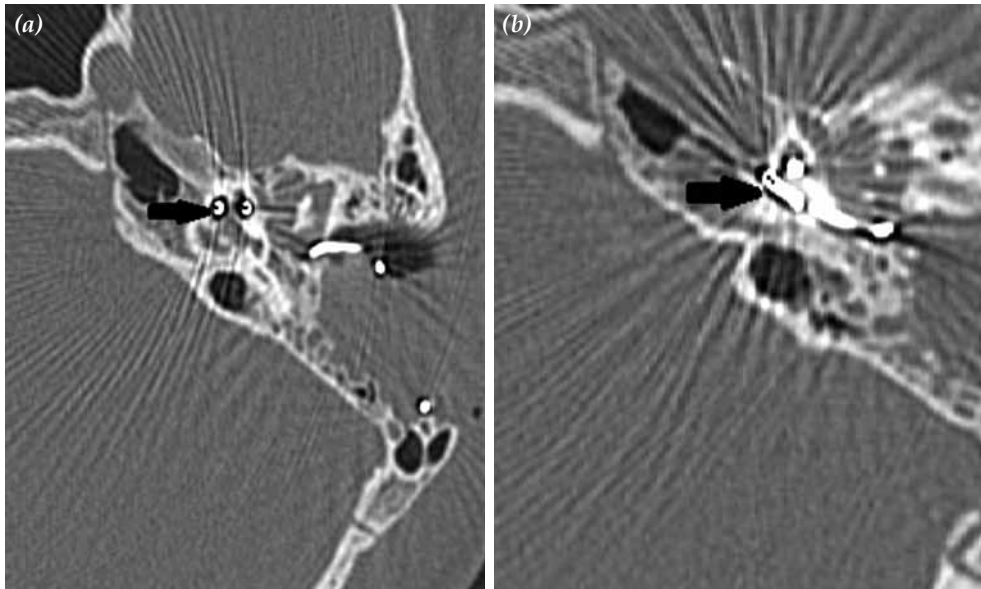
Postoperative temporal bone high resolution computed tomography of the left ear shows cochlear implant properly positioned in the cochlea.
